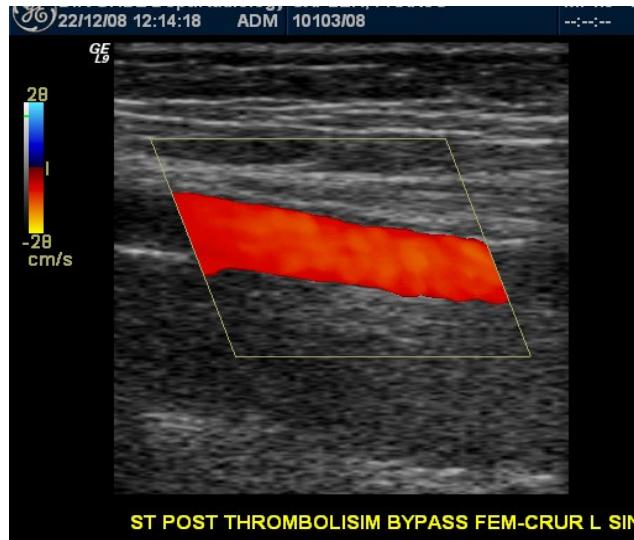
Demonstration of flow in the arterial bypass by color Doppler. The flow is coded in red color, directed away from the transducer (from the left to the right side on the image), and the ultrasound beam is electronically steered so that the color box is parallelogram, while the B-mod image is rectangular, since the examination was performed using the linear high-frequency transducer.
